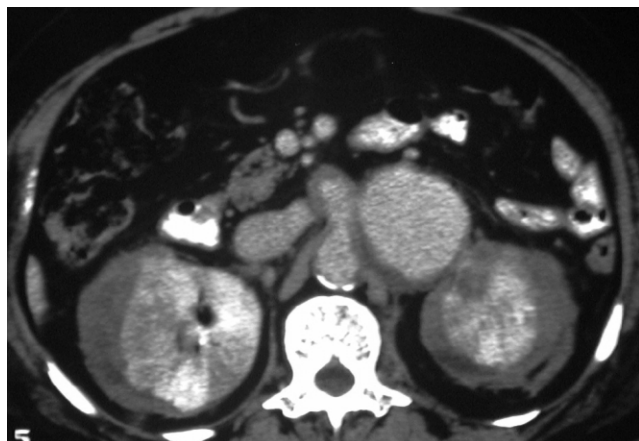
Abdominal CT scan shows a large aneurysm at the left anterior portion of the aorta and subcapsular hematoma surrounding both kidneys. Small calcifications are also seen in the posterior wall of the aorta.
